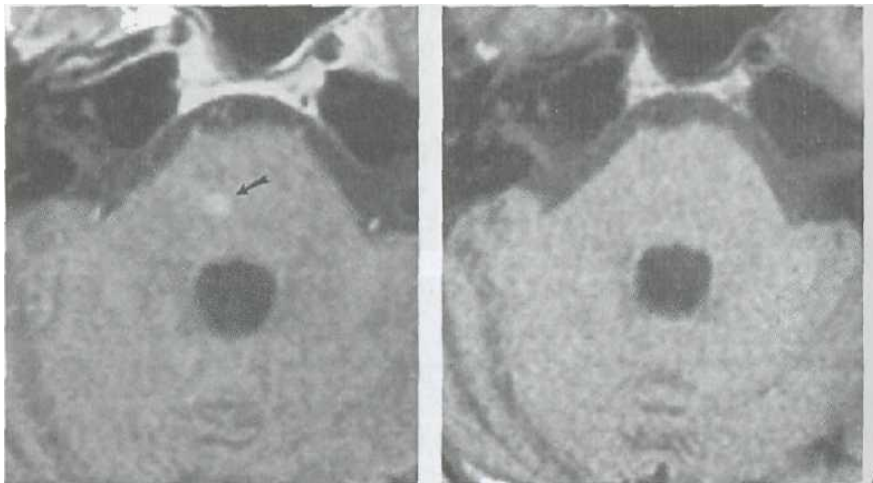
T₂-weighted MRI scans of a pontine capillary telangiectasia with (A) and without (B) gadolinium.
